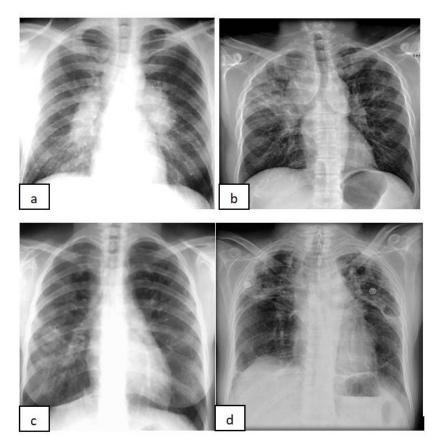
Pulmonary sarcoidosis-Stadialization of radiographic aspects. (a) Stage I -nodular opacities located hilar bilaterally. (b) Stage II-hilar opacities and Upper pulmonary infiltrates. (c) Stage III- infiltrate medio-pulmonary in right lung. (d) Stage IV-Scar reticulation opacities, retractances in the upper bilateral lobs.
